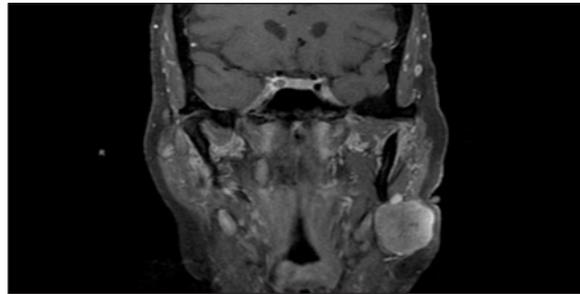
Magnetic resonance image, coronal cut. Coronal T1 image of tumor shows a left parotid mass.
